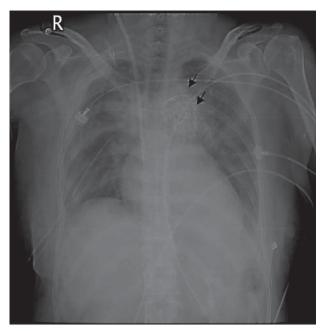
Chest x-ray scan: An endovascular graft stent was implanted at the isthmus of the aorta (black arrow).
